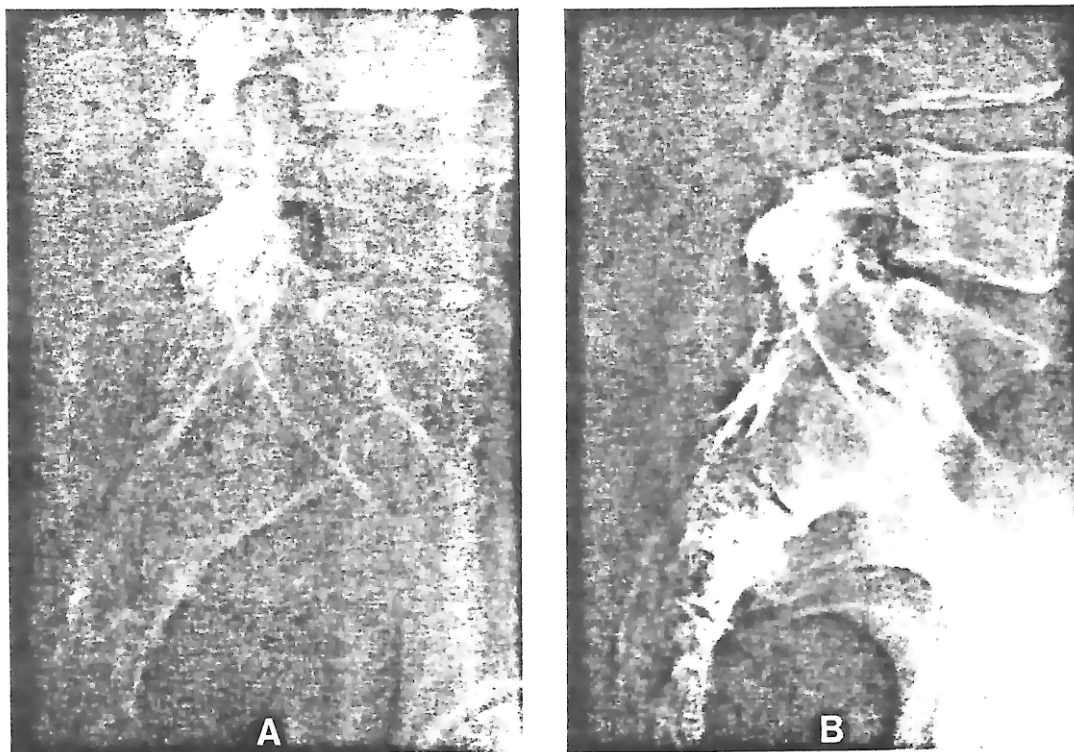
Comparison lateral sacral spine radiographs at 116 kVp (3 Φ). Subject measured 33 cm and radiation field was 20 cm \times 30 cm: (a) 12:1, 40.6 lines/cm grid using 300 mA at 0.07 s, 102 cm SID, 520 mR entrance skin exposure; (b) SMA using 600 mA at 1/3 s, 122 cm SID, 760 mR entrance skin exposure. Both exposures employing a nominal 1.2 mm focal spot with same cassette using Kodak Lanex screens combined with Kodak Ortho-G film. The films were developed within minutes of each other in the same processor. The same generator was employed for both films and the HVL's of the two source assemblies used were matched at 3.9 mm of Al at 80 kVp.
